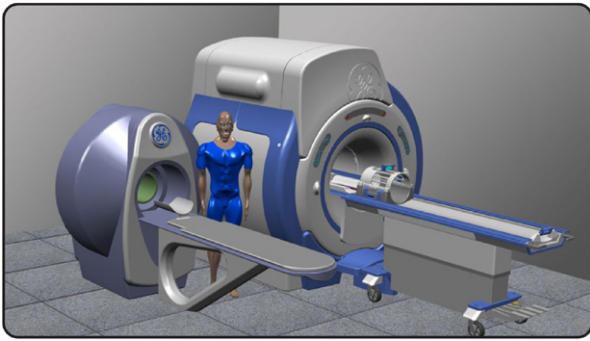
A dedicated head scanner in comparison to a standard 3 T whole body MRI system (artist's rendition).
